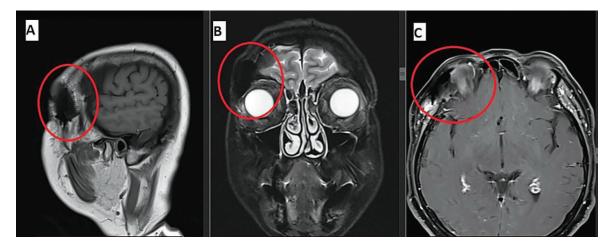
Postoperative sagittal (A), coronal (B) and axial (C) MRI images of the head; the postoperative changes, where the extirpated lesion was once located, are shown with red circle
